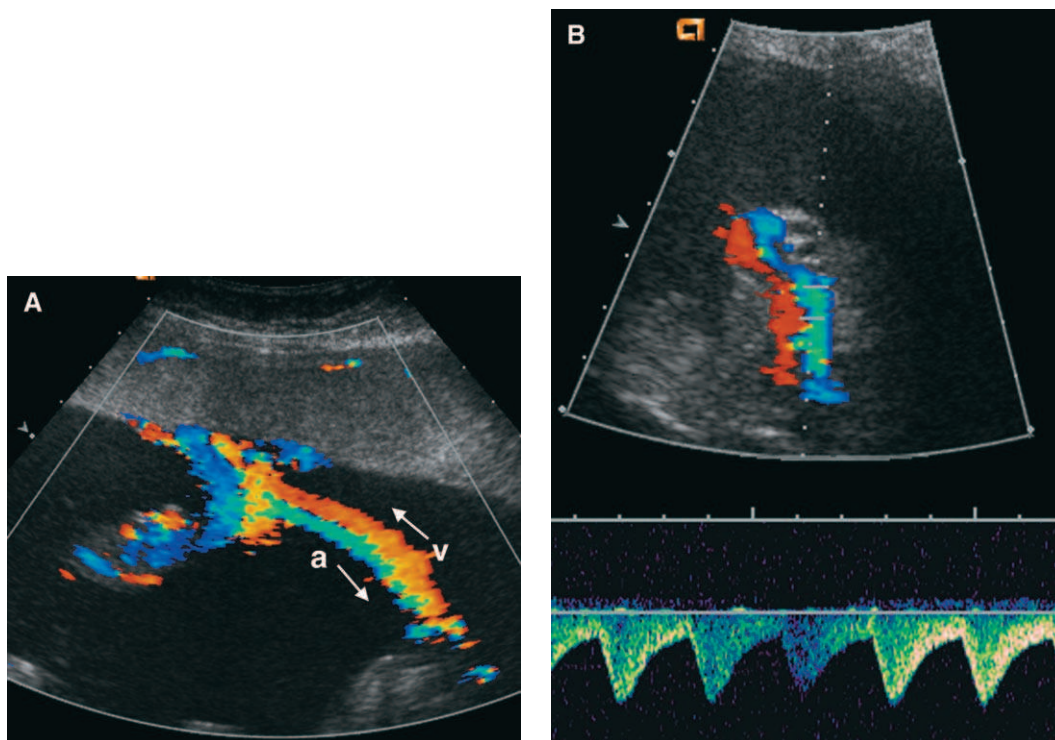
Twin reversed arterial perfusion sequence. (A) Color Doppler sonogram shows close proximity of the two umbilical cord insertion sites at the shared anterior placenta. Flow direction (arrow) within the umbilical artery (a) of the acardiac twin is reversed. (B) Reversed umbilical arterial blood flow, away from the placenta and toward the abdomen, is shown on spectral Doppler interrogation of the acardiac twin.
